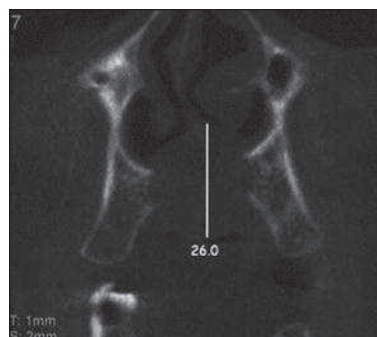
Coronal section of CBCT scan shows that radiolucent expansion at the anterior palate and nasal septum deviation to the right side (Case 2).
